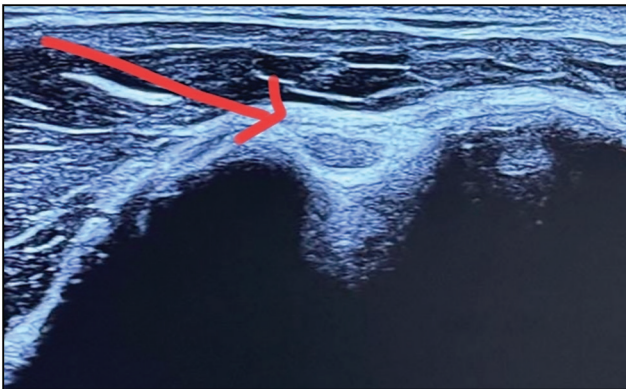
Ultrasound-guided image showing the bicipital tendon in the short-axis view
